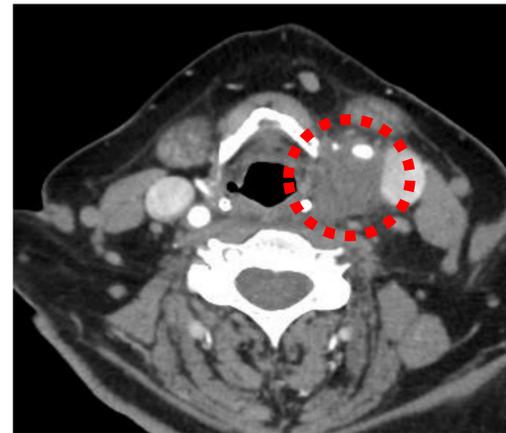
Neck CTA with soft tissue density.
